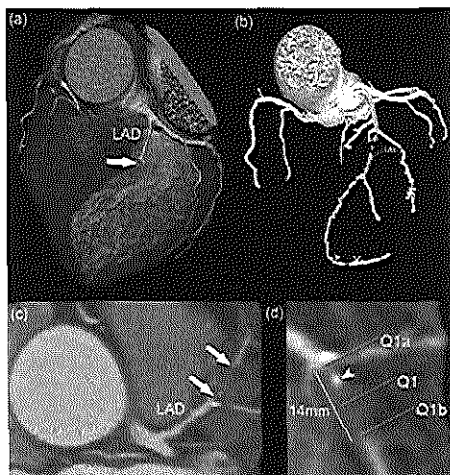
Measurement of the length of the occlusion by computed tomography coronary angiography. CT images showing an occlusion of the left anterior descending coronary artery (LAD). (a) Volume-rendered image showing the proximal part of the occlusion (arrow). (b) Using the Circulation® software the entire coronary tree can be extracted from the dataset. The start and end points for the vessel to be examined, in this example the LAD, are marked and a centreline through the middle of the vessel is displayed and labeled between these 2 points. (c) Maximal intensity projection showing the approximate length and composition, in this case non-calcified, of the occlusion. (d) After defining the centreline of the occlusion such as length and composition can be evaluated. The markers Q1a and Q1b set the boundary marker at the beginning and end of the occlusion, which in this case measures 14mm. The proximal part of the occlusion shows a small amount of calcium (arrowhead).
